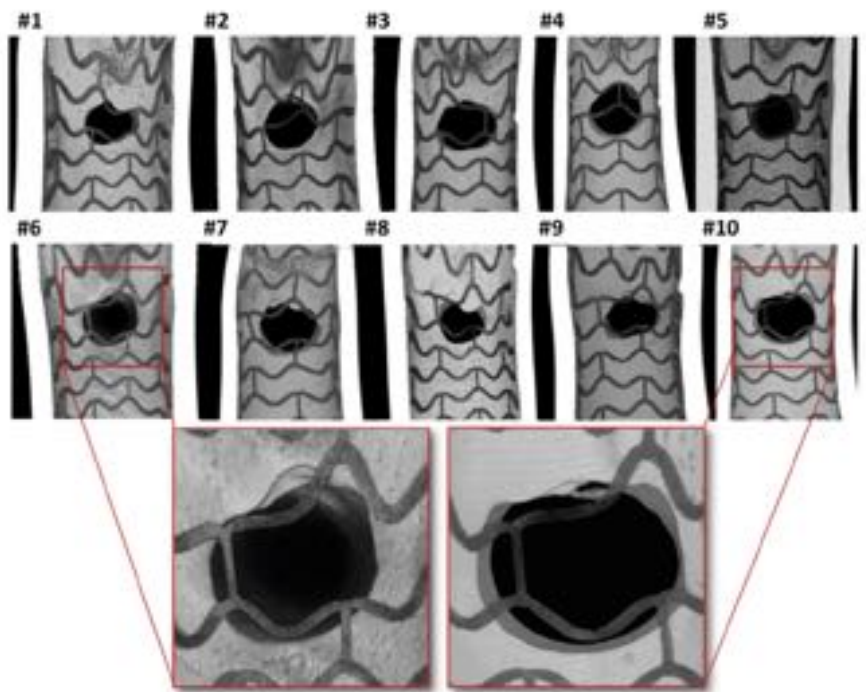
Microfocus X-Ray Computed Tomographic Close-Up of 20 Side Branch Ostia After Re-POT With Absorb Scaffold
